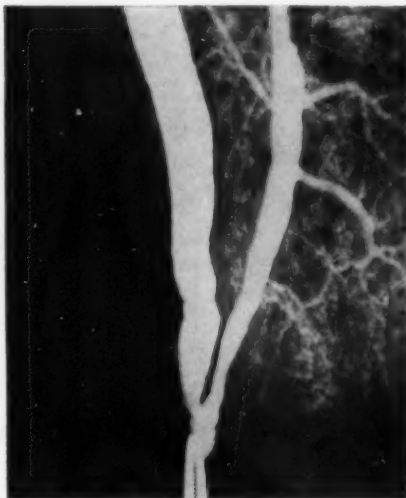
Radiograph of common and pancreatic ducts injected with barium sulfate. There is common roughening of both ducts, and small branches can be seen entering common duct in the intra-duodenal portion.
